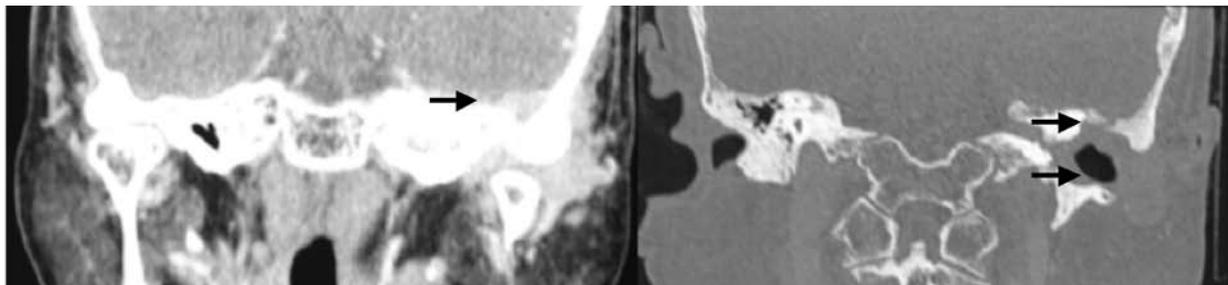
CT scan showing (left) moderate enhancement of the meninges in the left temporal lobe (arrow) adjacent to (right) the cortical defect in tegmen tympani (upper arrow) and mastoidectomy defect in the left mastoid with soft tissue density representing cholesteatoma and granulation tissue (lower arrow).
